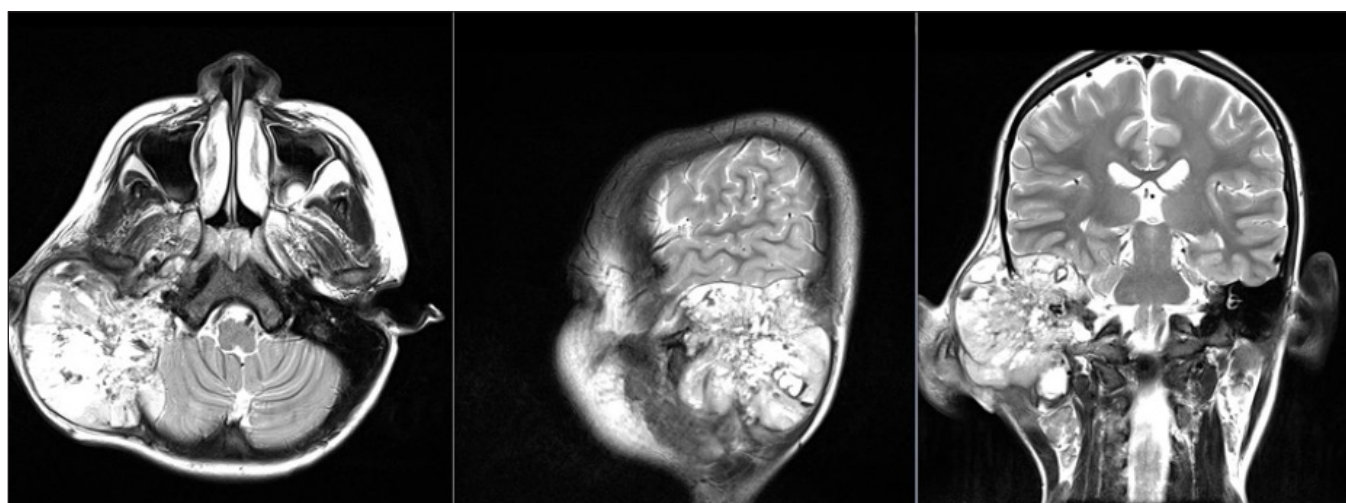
MRI of the patient. T2W1 with contrast.
